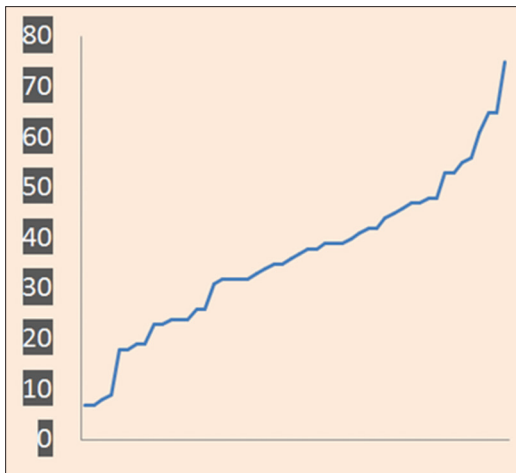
Line chart showing the distribution of persons in all age groups in the Doppler study group – X-axis in years
